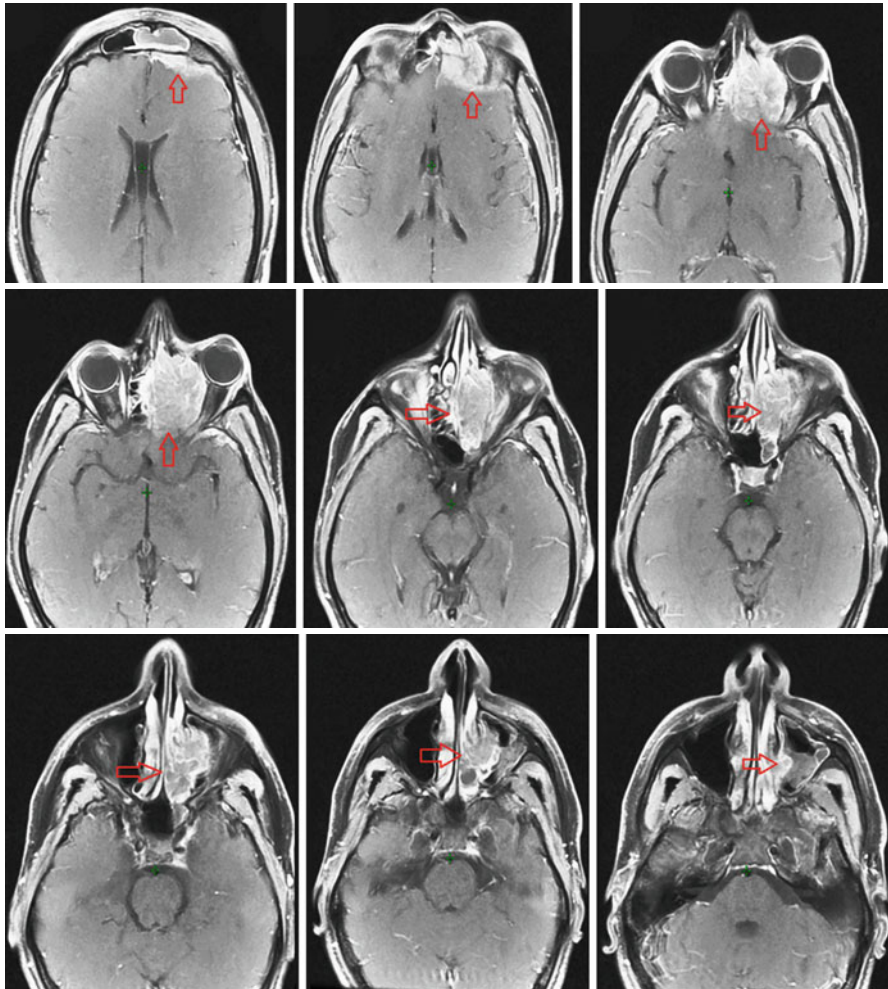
A giant mass completely obliterating the superior 2/3 portion of the left nasal cavity and eroding superior nasal conchae seen on MRI
